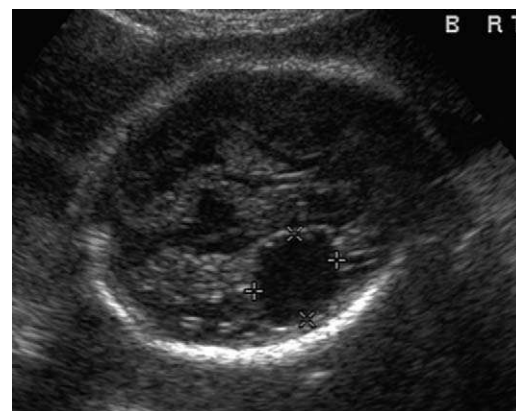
Ultrasound of fetus at 31 weeks' gestation with a cystic brain lesion (*calipers*). This examination was performed 3 days before the MR examination. This was a fetus from a triamniotic dichorionic triplet pregnancy with demise of one of the monochorionic pair. A repeat US (not shown) performed immediately before the scheduled MR examination showed demise of this fetus, and the MR examination was cancelled.
